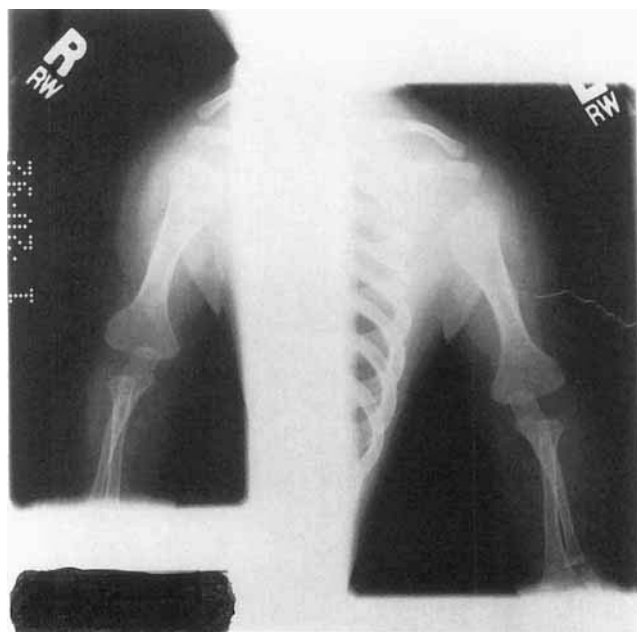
Radiograph of upper arms and forearms at age 10 months of patient 1. Note short, thick humeri with wide metaphyses and mildly bowed radii.
